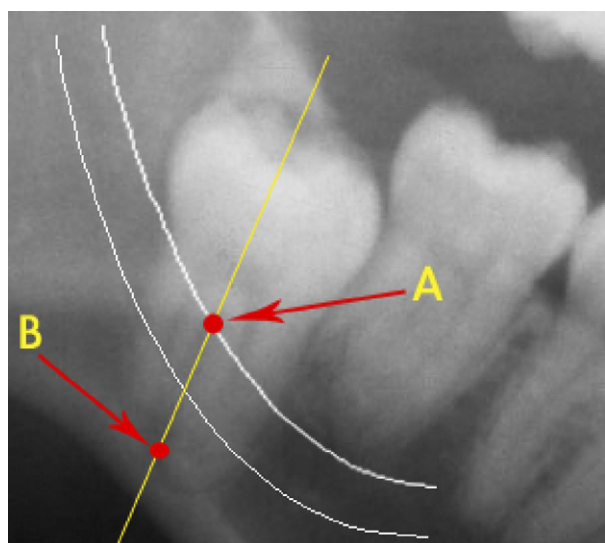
Radiographic measurement of the root position in relation to the inferior alveolar canal: the distance between point A (interception of the upper white line of the inferior dental canal and the long axis of root) and point B (the apex of the root along the long axis).
